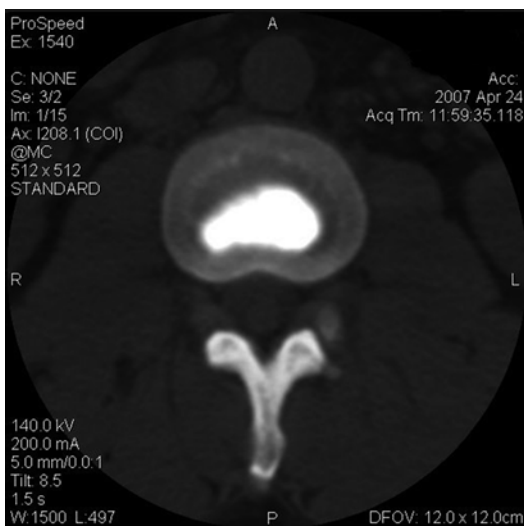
Axial post-diskography CT scan with grade 1 annular tear. Contrast extends slightly into the inner annulus in the right posterior quadrant
